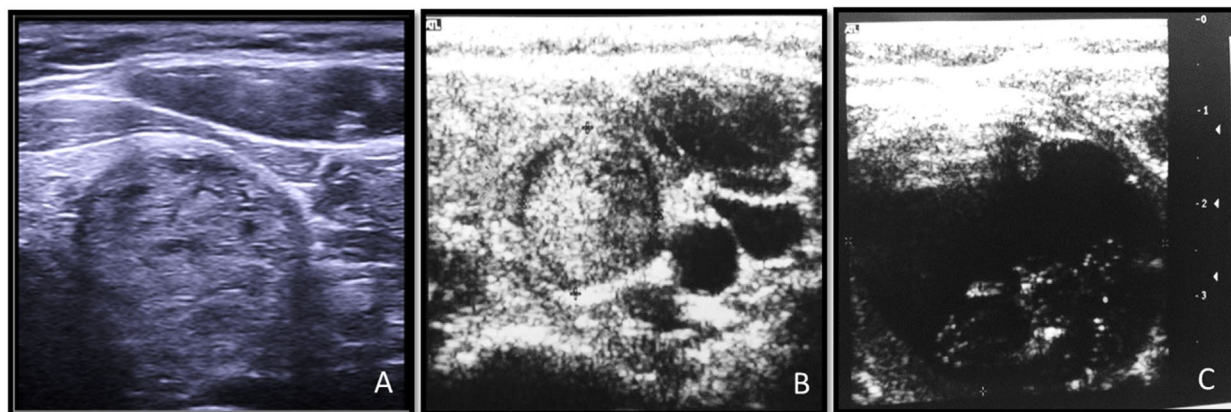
Different sonographic patterns of thyroid nodules. TR2: A Mixed solid and cystic isoechoic nodule. B Isoechoic solid nodule with regular border. C Thyroid nodule, partially solid and cystic
